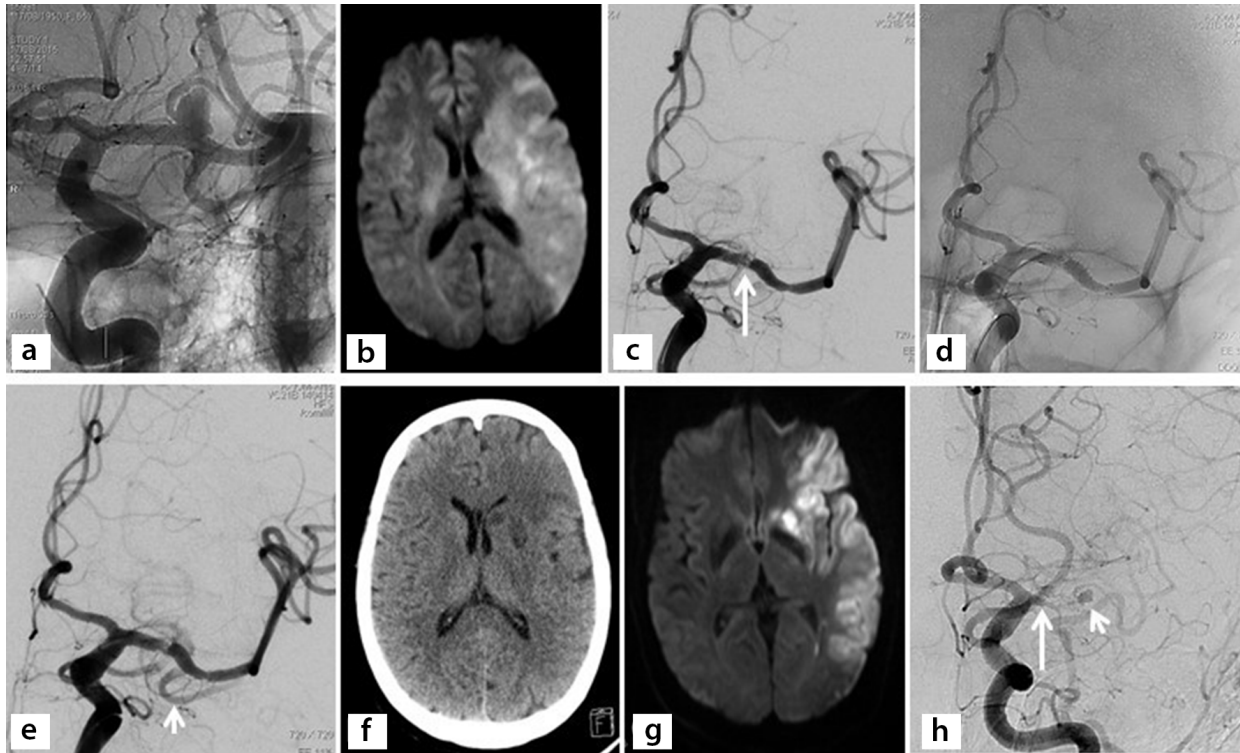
Seventy-five-year old, female. (a) Left M1 frontal branch origin aneurysm is treated with FRED. The stent is seen as entirely normal. (b) Two hours after anesthesia, the patient develops aphasia and right hemiparesis. DWI reveals acute ischemic stroke in MCA territory. (c, d) Immediate angiography shows the occlusion of both the frontal branch and the anterior temporal artery, and the aneurysm. There is also a partial thrombus within the stent lumen (long arrow). Also, note the dysmorphic changes -the fish mouth- in the stent. (e) 2 mg of IA tirofiban only enables the slow perfusion of the anterior temporal artery (short arrow). (f, g) Next day CT and DWI show no bleeding, but the acute ischemic changes despite the IV tirofiban infusion. (h) 6th-month follow-up DSA shows the total occlusion of the stent (long arrow). The aneurysm is still filling through collaterals to the lenticulostriate arteries (short arrow). FRED, flow re-direction endoluminal device; DW, diffusion-weighted imaging; MCA, middle cerebral artery; CT, computed tomography; DSA, digital subtraction angiography.
